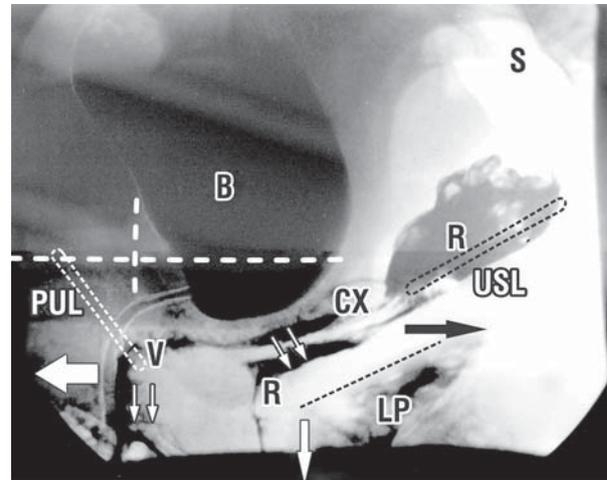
A sitting X-ray taken in the straining position, with radio-opaque dye injected into the bladder (B), vagina (V), rectum (R), levator plate (LP). PUL and USL represent the pubourethral and uterosacral suspensory ligaments. The organs are tensioned like a trampoline by the muscle forces (arrows) contracting against the suspensory ligaments.
